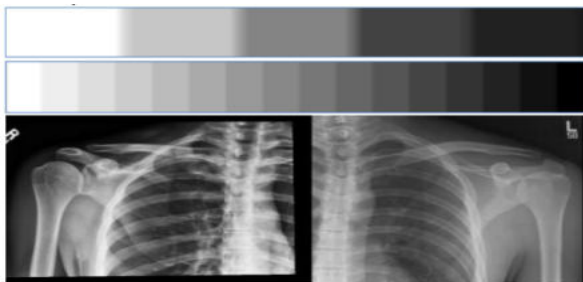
The difference in density (contrast contrast) between adjacent anatomical structures must be at least sufficient to reflect different shades of gray. Two adjacent points on an x-ray rendered in the same shade of gray represent a structure for the human eye.
